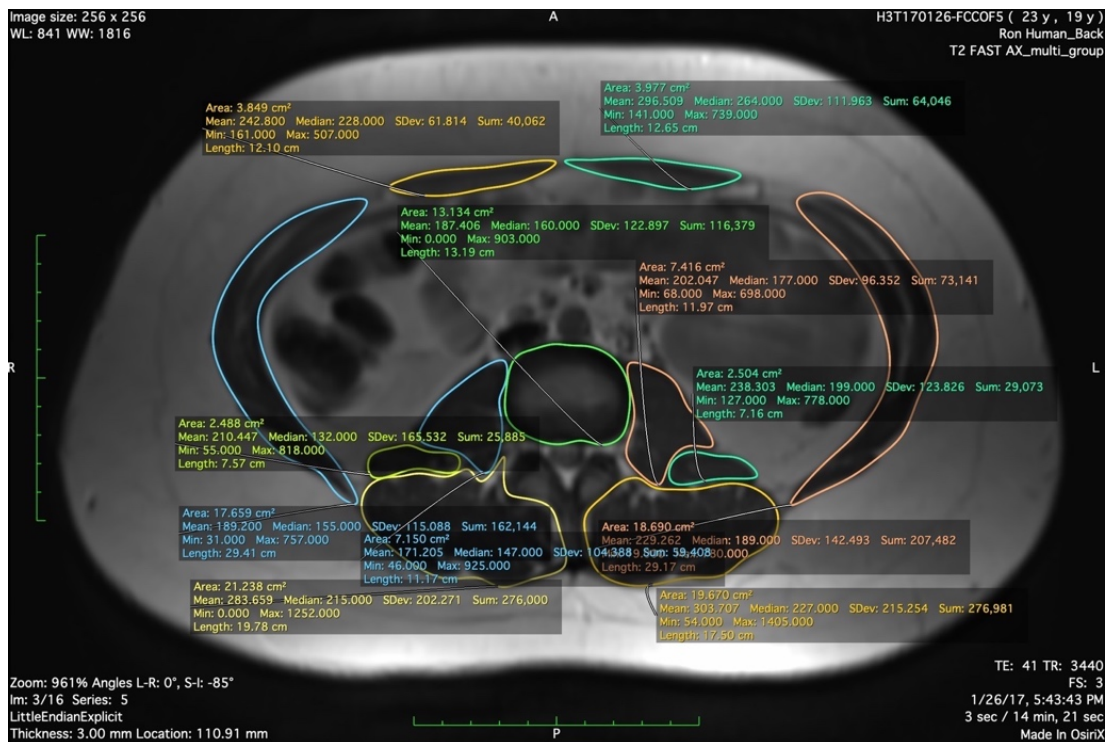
Traced MRI with Muscle CSAs Calculated in OsiriX
